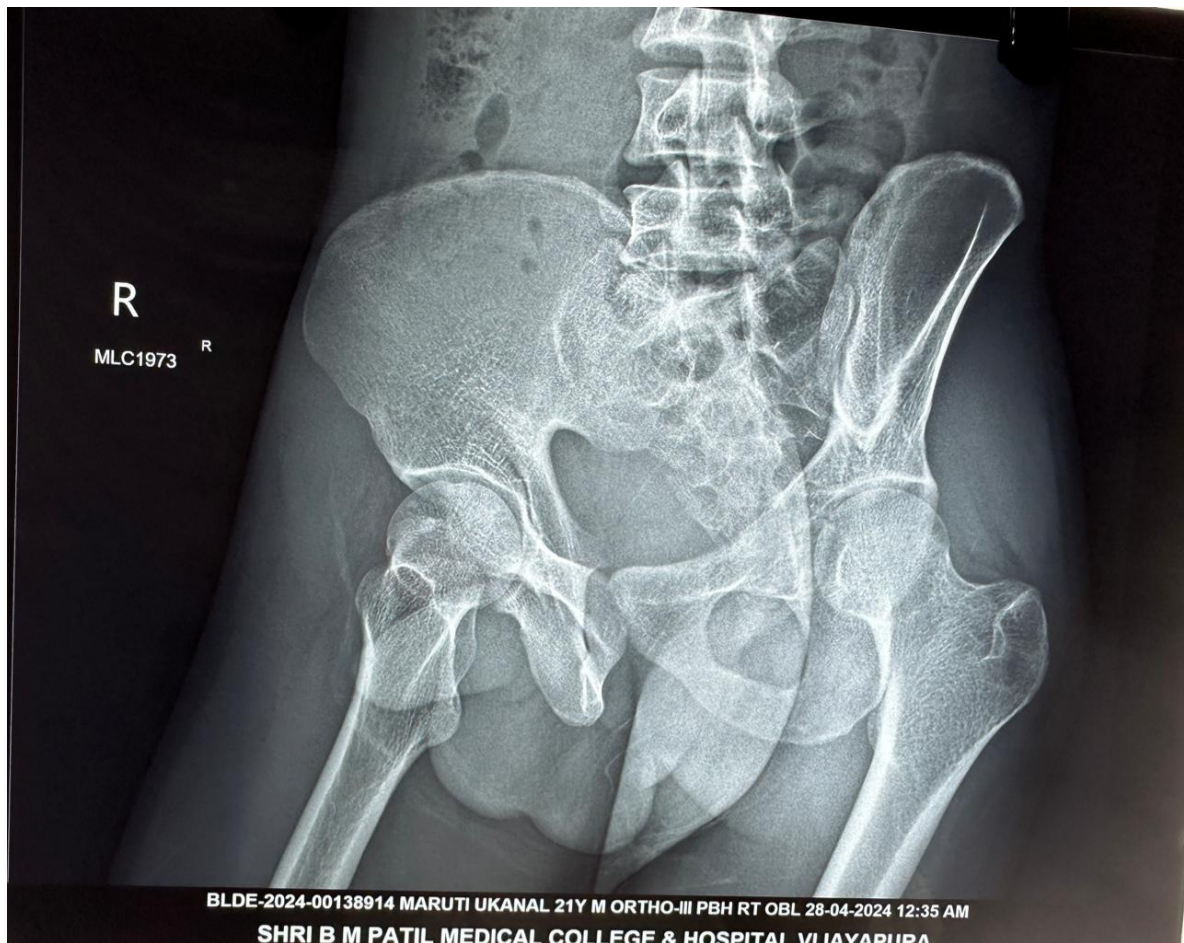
Right Iliac Oblique X-ray radiograph
